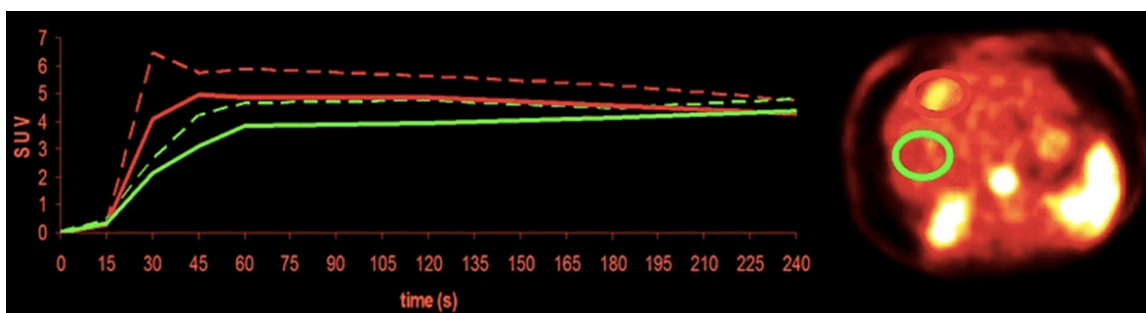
Time activity curves of normal liver and tumor (HCC) from dynamic FDG PET images (image at 30-45 second). Tumor curves show faster influx and higher peaks than liver tissue (due to increased arterial perfusion), followed by slower drop, which reaches non-tumor levels after more than 3 min (green normal liver, red tumor). Re-printed with permission from Society of Nuclear Medicine and Molecular Imaging [13].
